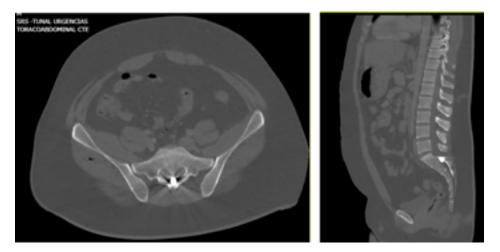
Computed tomography of the lumbosacral spine showing a projectile lodged in the vertebral canal at S1-S2. A) Axial view B) Sagittal view. Source: Image obtained while conducting the study.
